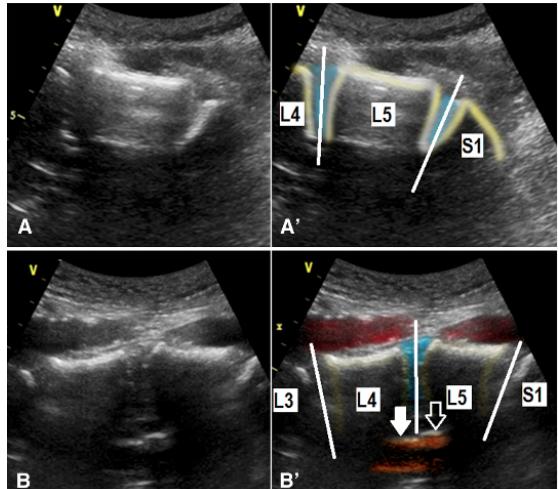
Longitudinal ultrasound scans of the spinal column showing clear, high quality results. [21]
